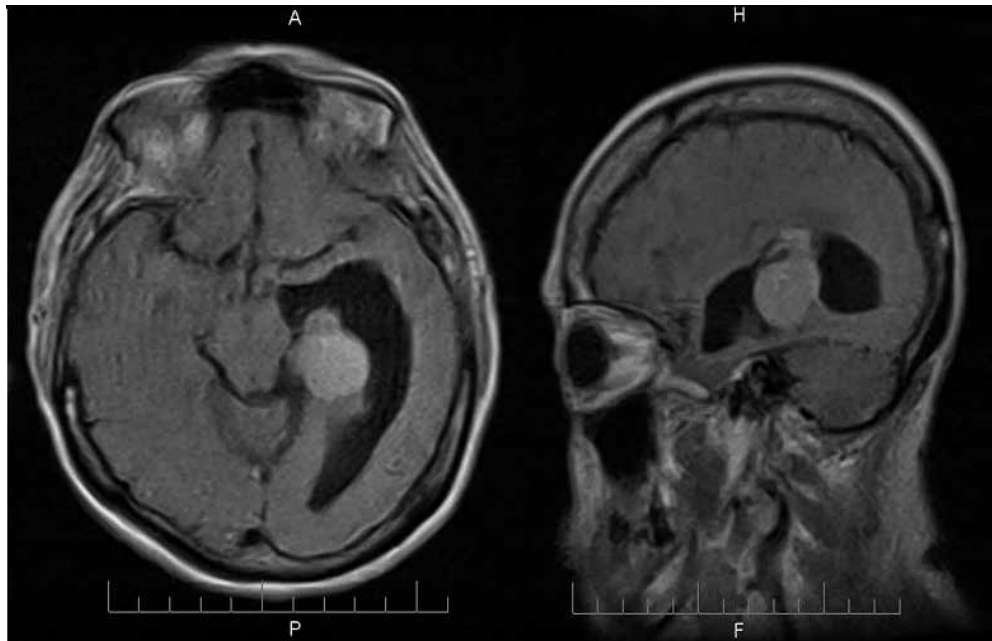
Magnetic resonance images showing the left intraventricular tumor
